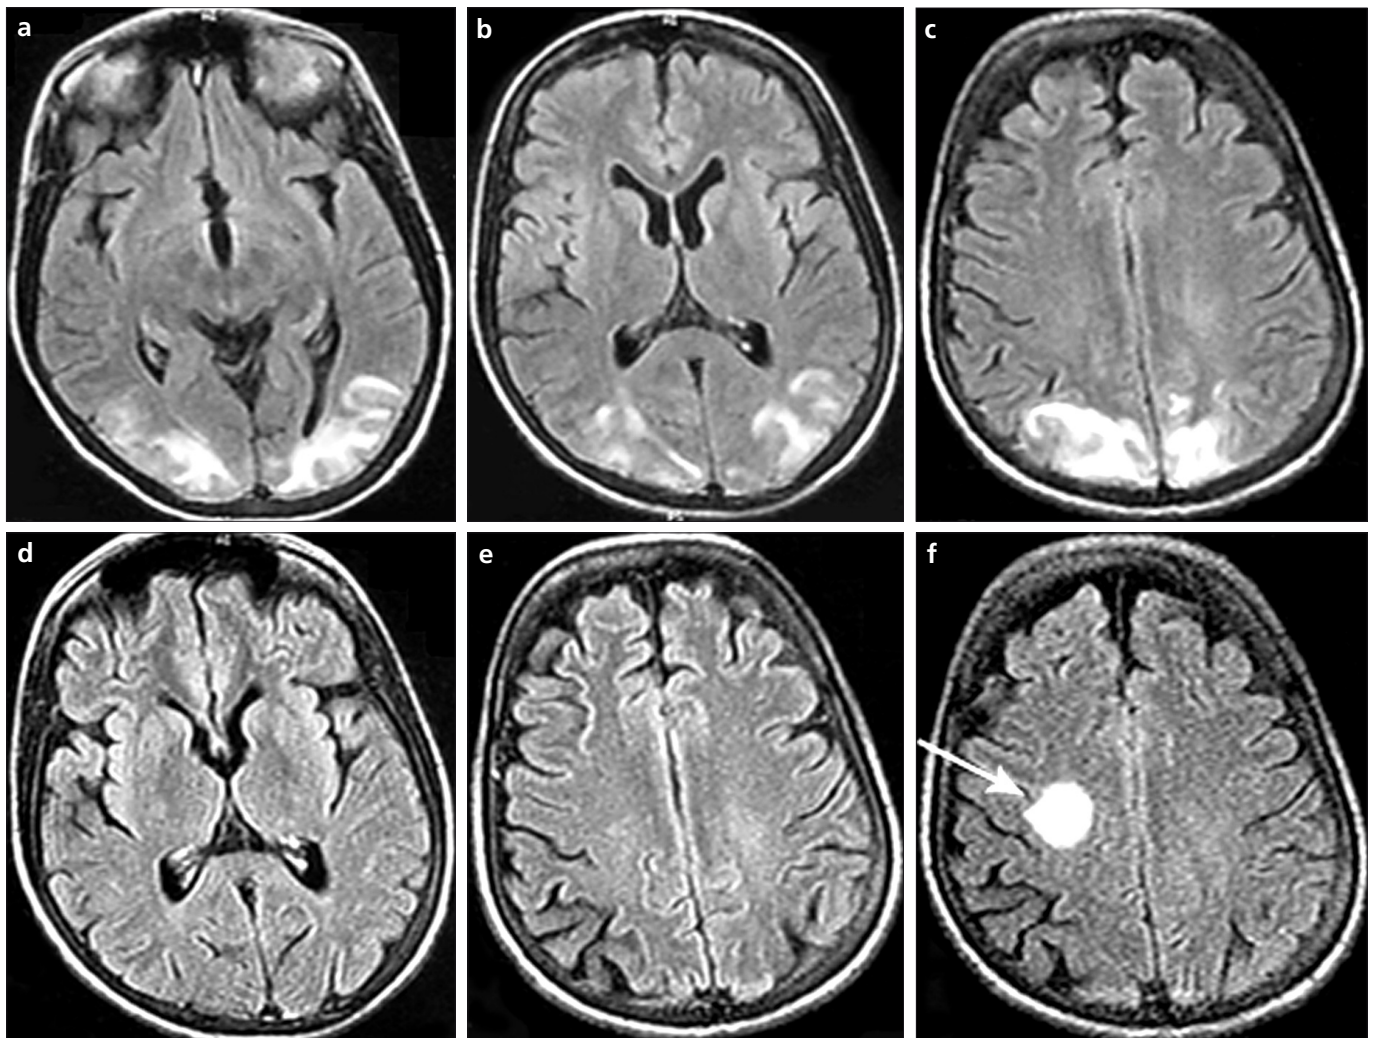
a–f. Axial FLAIR MR images (a–c) show symmetrically-located, bilateral, hyperintense lesions in the parietooccipital regions affecting the cortex and subcortical white matter. On the follow-up MR image (d, e), the edema has completely resolved. On axial FLAIR MR image obtained (f) six weeks later, there is a 2-cm edematous lesion at the right centrum semiovale (arrow), consistent with recurrent PRES.
